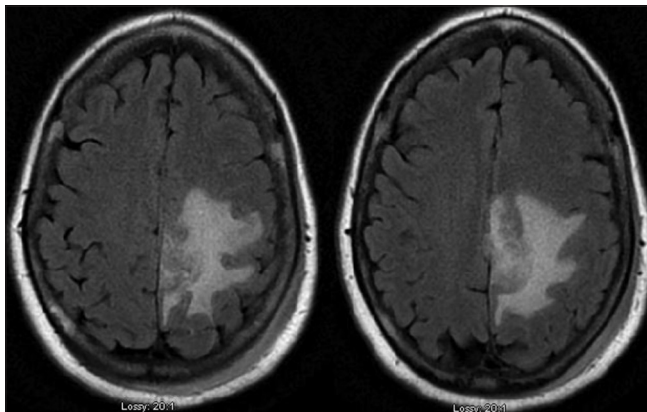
T2 FLAIR MRI one month after presentation
